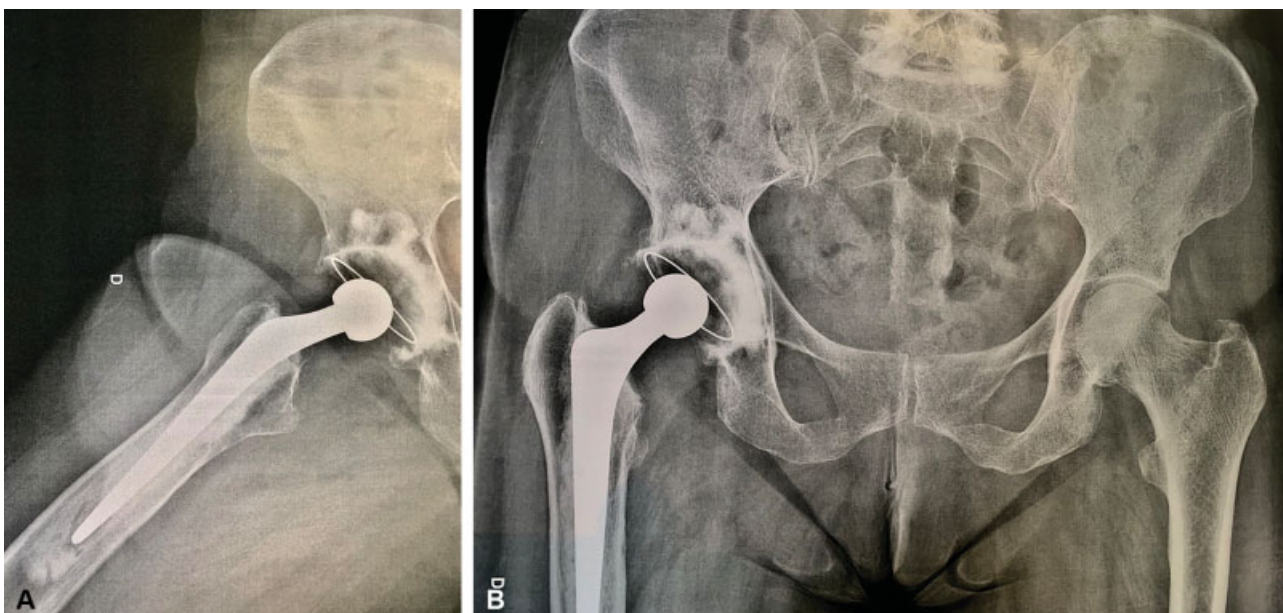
Postoperative radiographs in anteroposterior and lateral view of a 59-year-old female patient submitted to a cemented total hip arthroplasty due to primary hip osteoarthritis after 16 years and 3 months of evolution.
